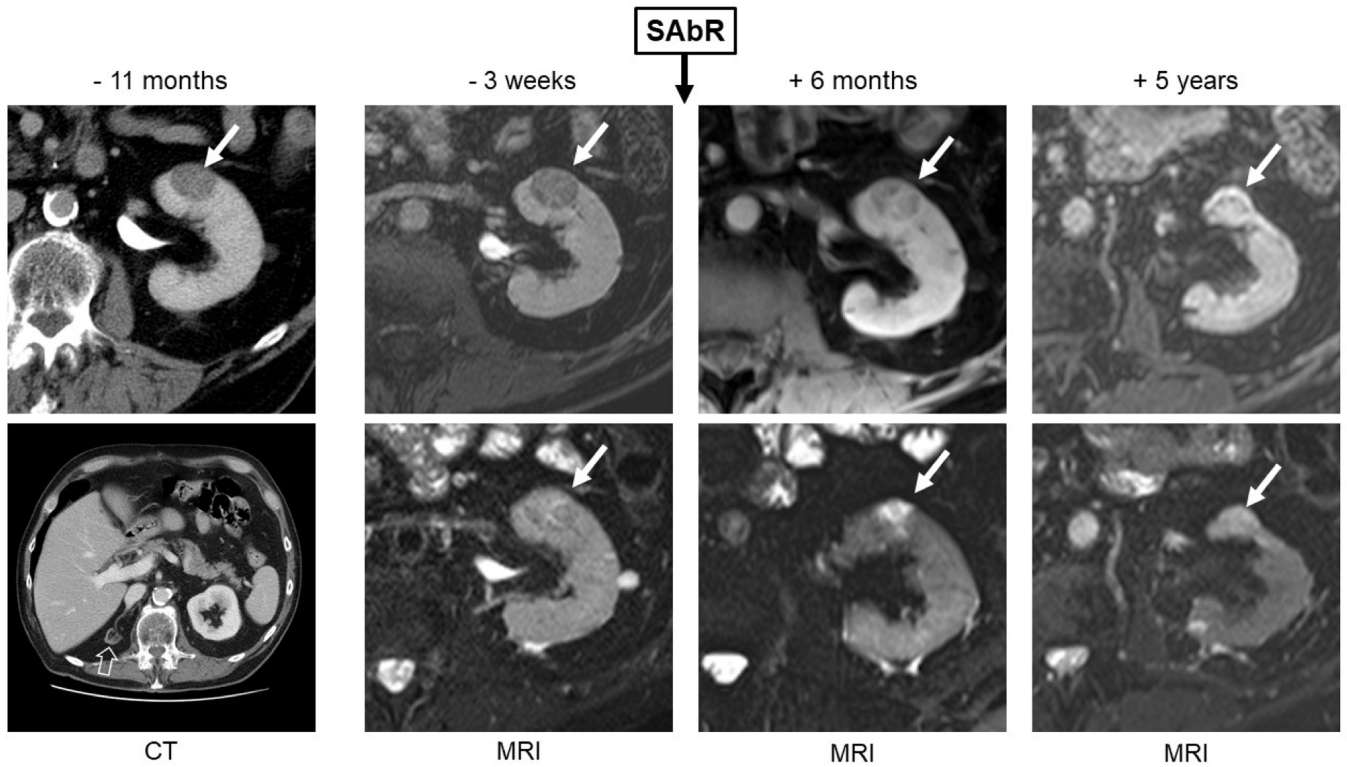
Initial computed tomography (CT) obtained 11 mo prior to SAbR, magnetic resonance imaging (MRI) obtained 3 wk prior to SAbR, and surveillance MRI at 6 mo and 5 yr after SAbR of a patient with a single functional kidney (ie, congenital atrophic right kidney; open arrow on baseline CT) and a left renal mass (solid arrow). Percutaneous biopsy confirmed grade 3 clear cell renal cell carcinoma. The renal mass exhibited growth from 2.5 cm (11 mo prior to SAbR) to 2.7 cm (baseline, 3 wk prior to SAbR). The patient was treated with 36 Gy in five fractions. Follow-up MRI showed a decrease in size on initial follow-up to 2.3 cm (6 mo after SAbR) and subsequently to 1.9 cm (5 yr after SAbR). T1-weighted fat-saturated gradient-echo contrast-enhanced images obtained during the delayed nephrographic phase (top row) show progressively increased enhancement after SAbR, while T2-weighted images (bottom row) show increased signal intensity after treatment suggestive of treatment-induced fibrosis in the renal mass. SAbR = stereotactic ablative radiotherapy.
